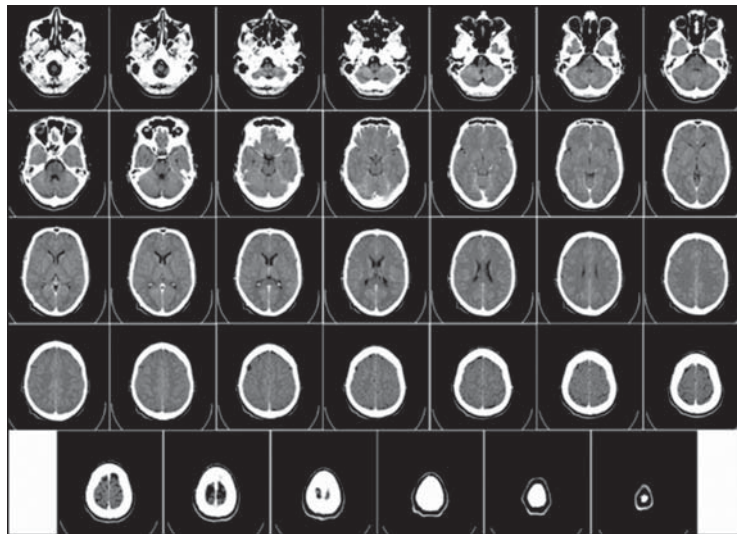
Computed Tomography of Human Brain, From Base of the Skull to Top. Taken with Intravenous Contrast Medium.
